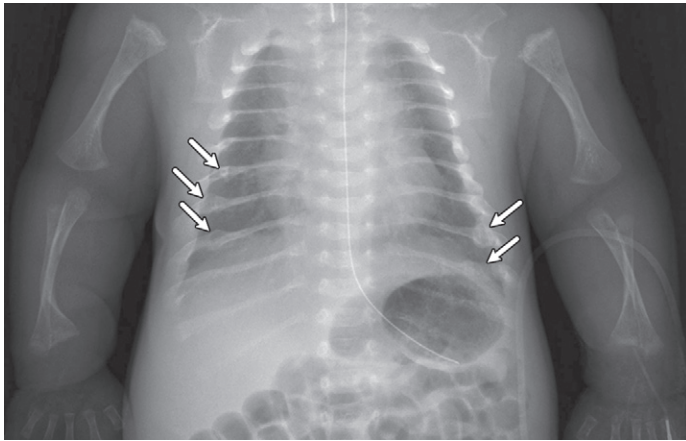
Diffusely thin ribs with fractures in a neonate with osteogenesis imperfecta. Frontal chest radiograph shows osteoporotic, diffusely thin, deformed ribs as a result of multiple fractures (arrows). The bilateral proximal humeri are osteoporotic with irregular proximal metaphyses. The vertebral bodies are compressed.
